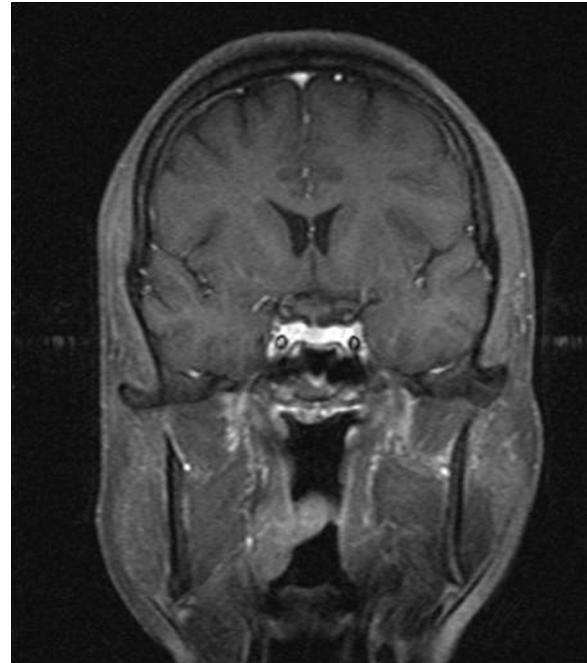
Follow up post treatment contrast enhanced MRI brain (Coronal view) showing resolution of the pituitary mass.
